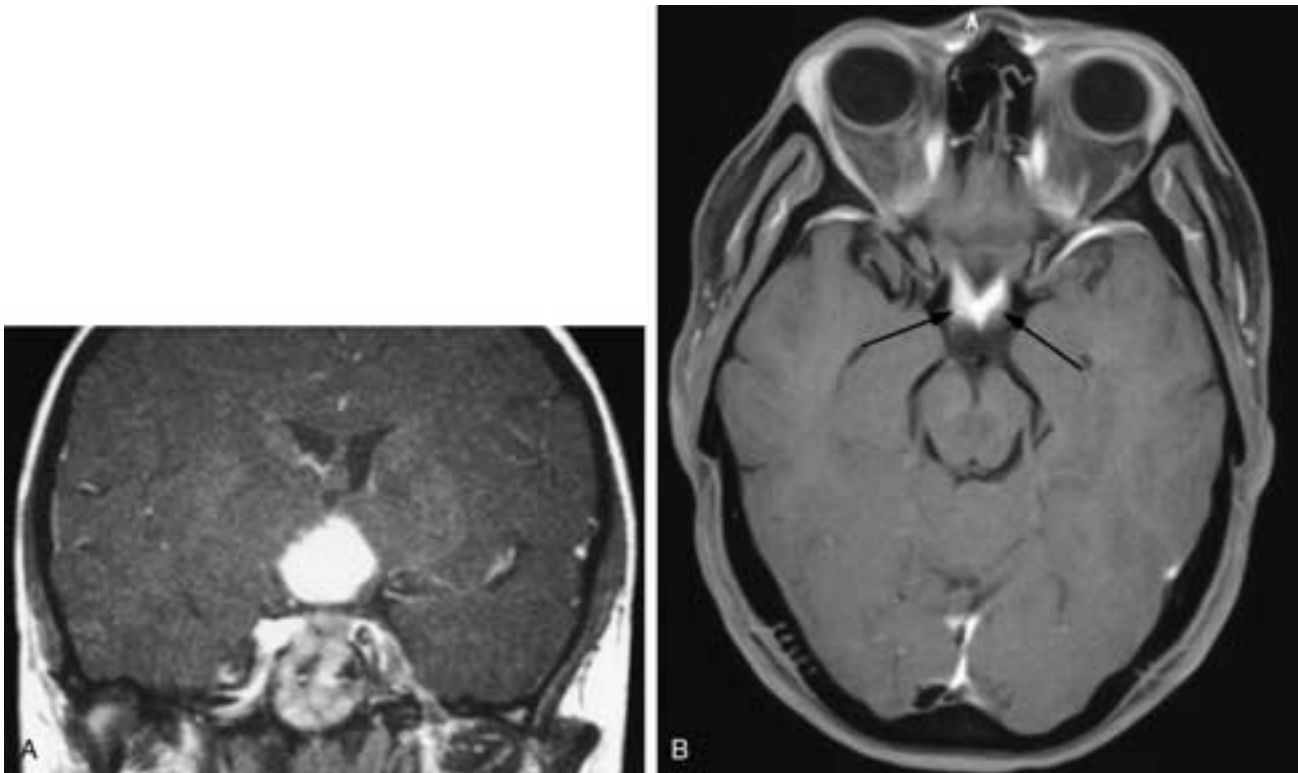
Sarcoidosis involving the hypothalamus and/or the optic chiasm. A, A 16-year-old female with hypothalamic dysfunction and visual impairment. Contrast-enhanced, T1-weighted coronal image shows a large enhancing mass. B, A 26-year-old female with chiasmatic and bilateral intracranial optic nerve involvement by sarcoid. Fat-suppressed, axial T1-weighted image after contrast injection shows enhancement of the areas of involvement (*arrows*).
